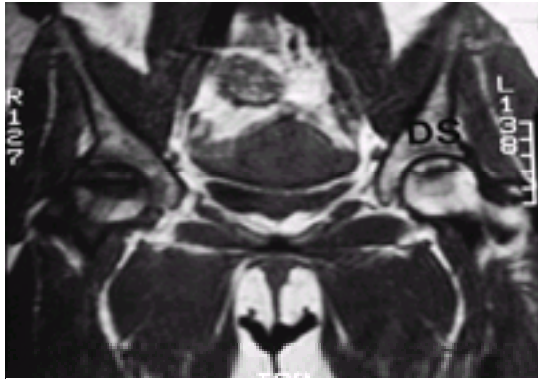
Femoral head infarcts on MRI.
